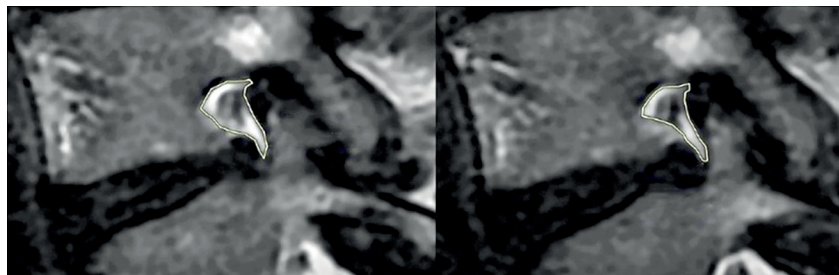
MRI of the right L4-L5 foramina without spinal loading alongside an MRI of the same foramina under axial loading. The area for measurement is highlighted in both images, and a decrease in the measured area is noted. Additionally, the MRI with loading shows a discernible decrease in the fat surrounding the nerve root. Figure 2 from “Axial Loading during MRI Induces Lumbar Foraminal Area Changes and Has the Potential to Improve Diagnostics of Nerve Root Compromise”, by Hebelka, H., Rydberg, N., Hutchins, J., Lagerstrand, K. & Brisby, H. J., published by MDPI in in J Clin Med. 2022 Apr 11;11(8):2122. Licensed under CC BY.
